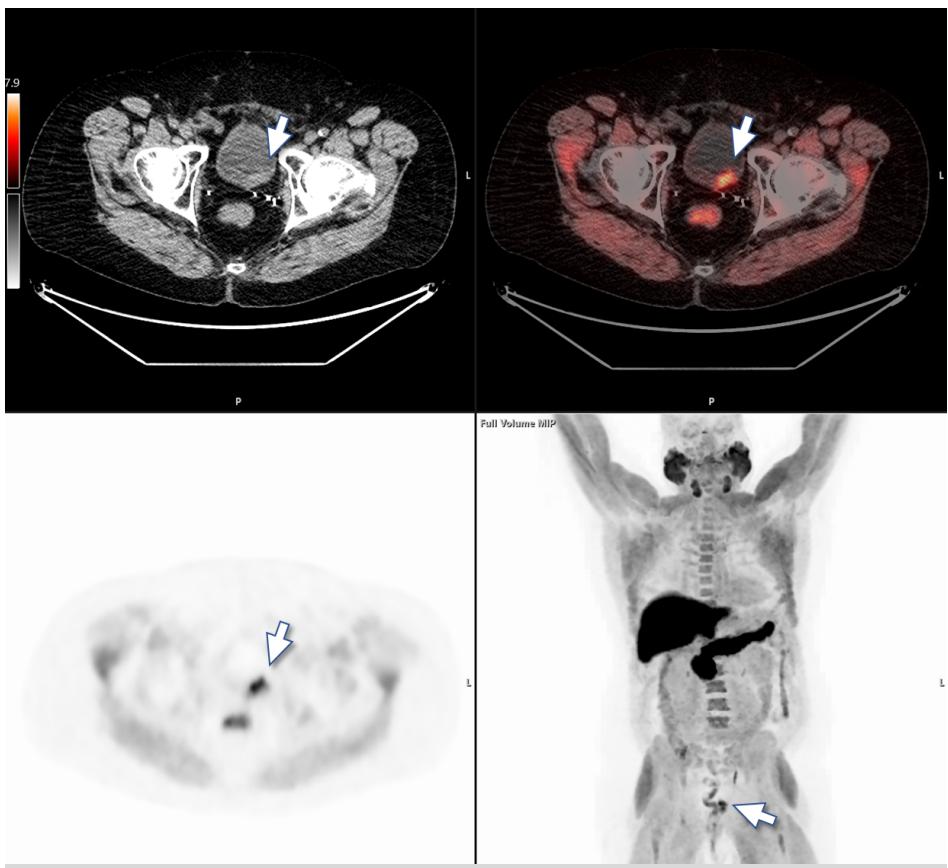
^{18}F -Fluciclovine PET shows bladder wall recurrence (arrow). The maximum intensity projection (MIP, lower right) also shows biodistribution of fluciclovine with intense physiologic uptake in the liver and pancreas. Normal bone marrow uptake in the lower lumbar spine and sacrum is absent due to prior radiation therapy. Unlike FDG and many other radiopharmaceuticals, fluciclovine is not significantly excreted in the urine, making it easier to see lesions in the pelvis and prostate bed.
